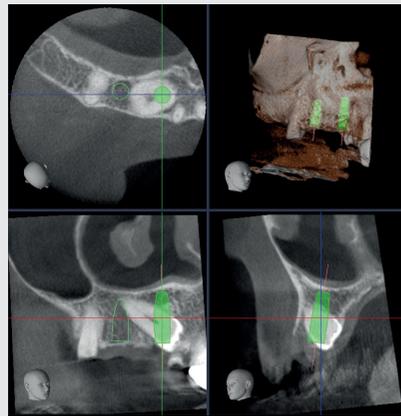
Implant planning on CBCT
